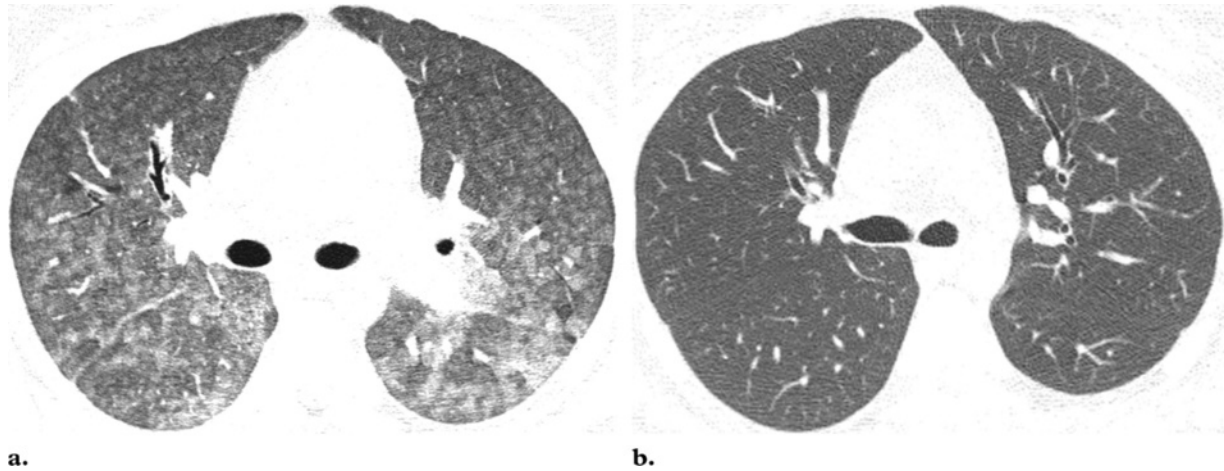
Insidious hypersensitivity pneumonitis in a 39-year-old woman with a history of exposure to parakeets and cockatiels. (a) Axial high-resolution CT image demonstrates extensive ground-glass opacity with a centrilobular concentration. (b) Axial CT image obtained after therapy and removal from exposure shows complete resolution.
